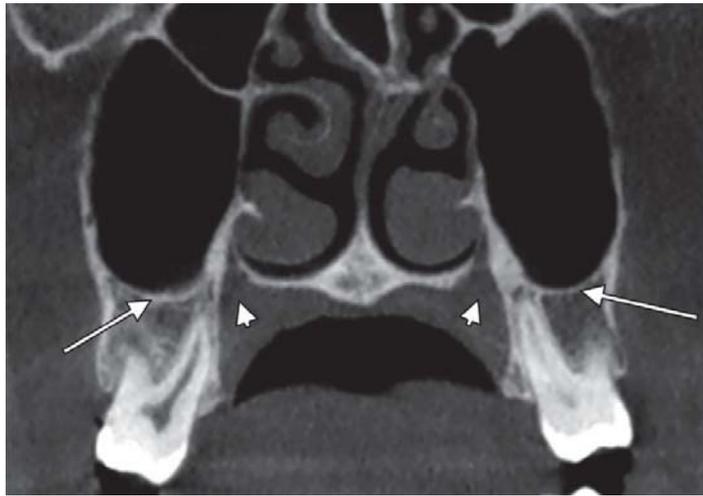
Coronal CBCT slice. The greater palatine foramina (arrowheads) are located at the level of the second maxillary molars (arrows)
